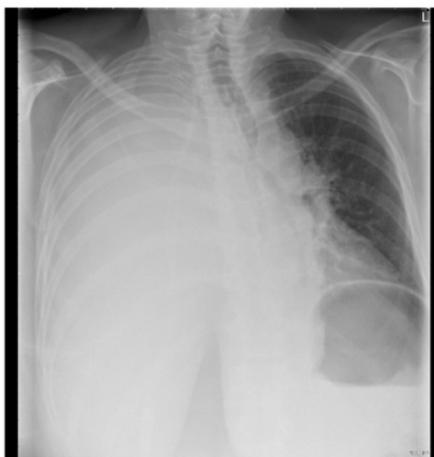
Chest X-ray demonstrates pleural effusion.
